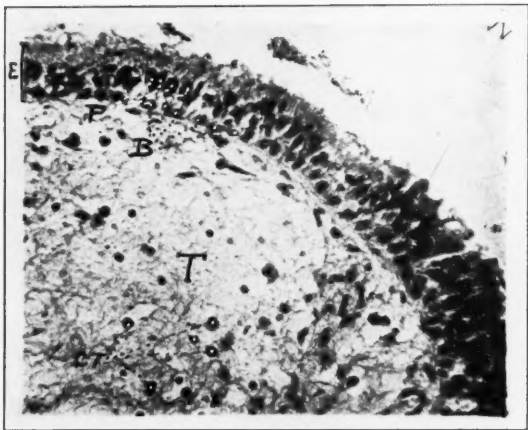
Mucosa of frontal sinus ($\times 473$). E—Stratified squamous epithelium thickened; cilia have sloughed. B—Basal cells. P—Pillar cells. T—Tunica propria, edematous; CT—Connective tissue cells.
